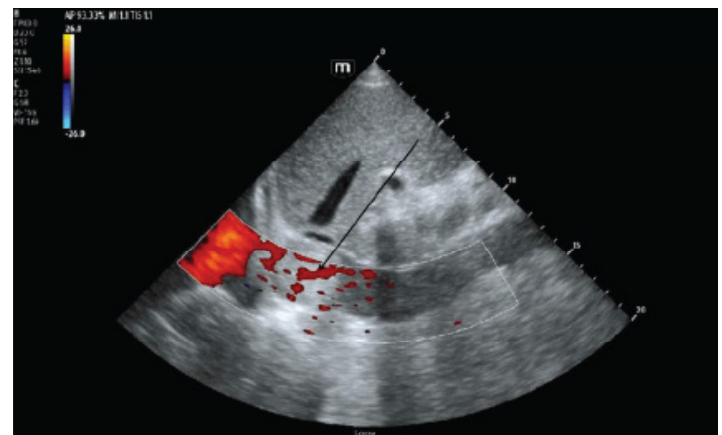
Point-of-care ultrasound of the inferior vena cava (IVC) with color Doppler applied showing poor venous return (arrow) to the right atrium secondary to IVC mass/tumor thrombosis.
